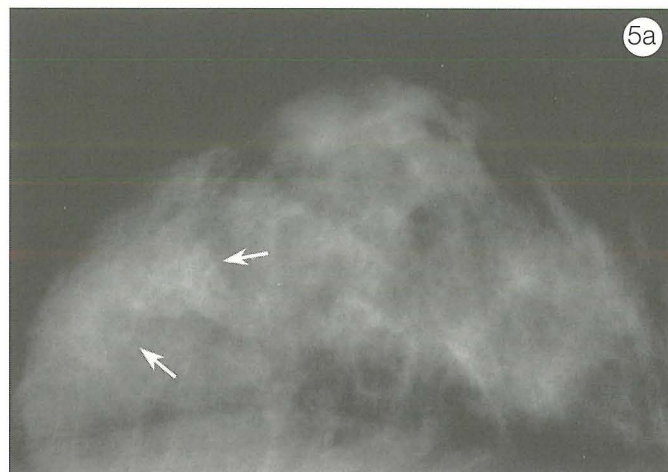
Diabetic mastopathy in a case of long-standing insulin-dependent type 1 diabetes mellitus that presented with a palpable mass. (a) Mammogram shows subtle foci of asymmetric density laterally at the location of the palpable mass (arrows). (b) Ultrasound reveals an irregular hypoechoic mass with ill-defined margins and discrete acoustic shadowing.
